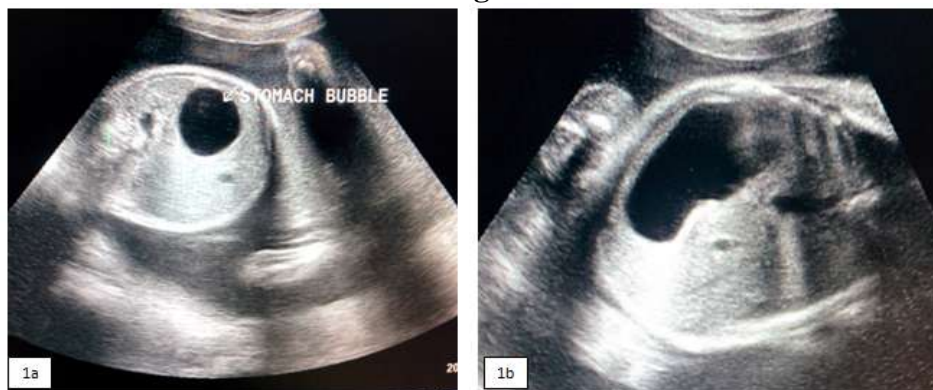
Antenatal ultrasonography images showing Dilated stomach bubble with paucity of bowel loops in the fetus – Pyloric Atresia
